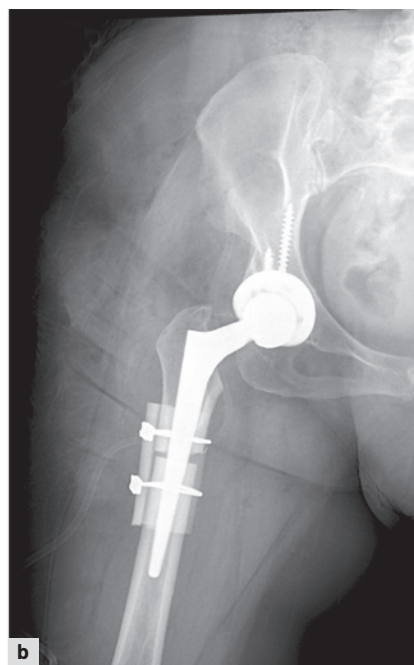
Patient 1, with Crowe type IV dysplasia: a – preoperative anteroposterior hip X-ray; b – postoperative hip X-ray; c – postoperative hip X-ray at 8 months (the smallest possible 44-mm acetabular component).
